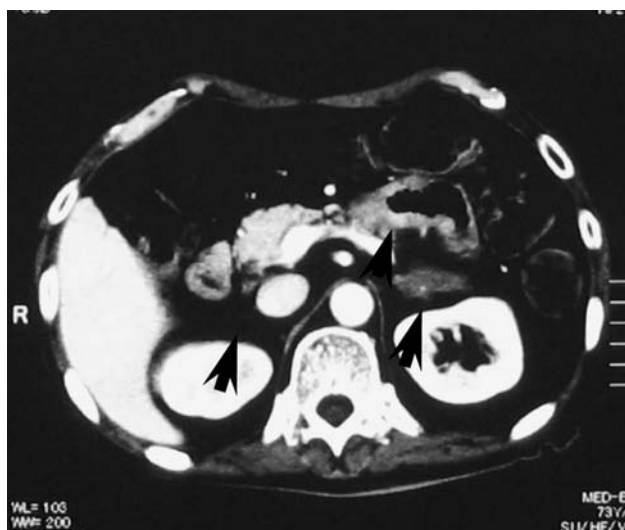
Abdominal computed tomography revealed the reduction of bilateral adrenal tumors and intestinal wall thickness (➡) after one cycle of the R-THP-COP chemotherapy
